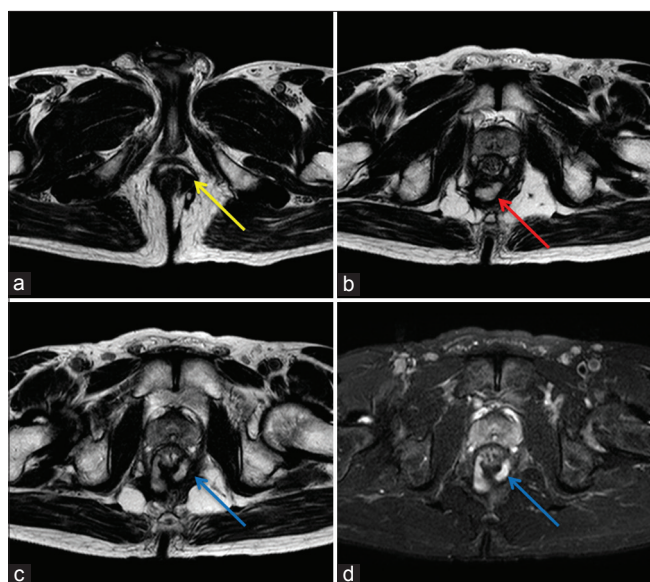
(a) Axial T2-weighted (T2W) image showing a hyperintense trans-sphincteric tract on left side (yellow arrow). (b) Axial T2W image showing the trans-sphincteric perianal fistulous tract now in the inter-sphincteric plane (red arrow). (c and d) Axial T2W and axial proton density images respectively shows the fistulous tract giving off branches in the inter-sphincteric plane, with separate internal openings at 3 o'clock and 9 o'clock on right and left side respectively (blue arrows)
